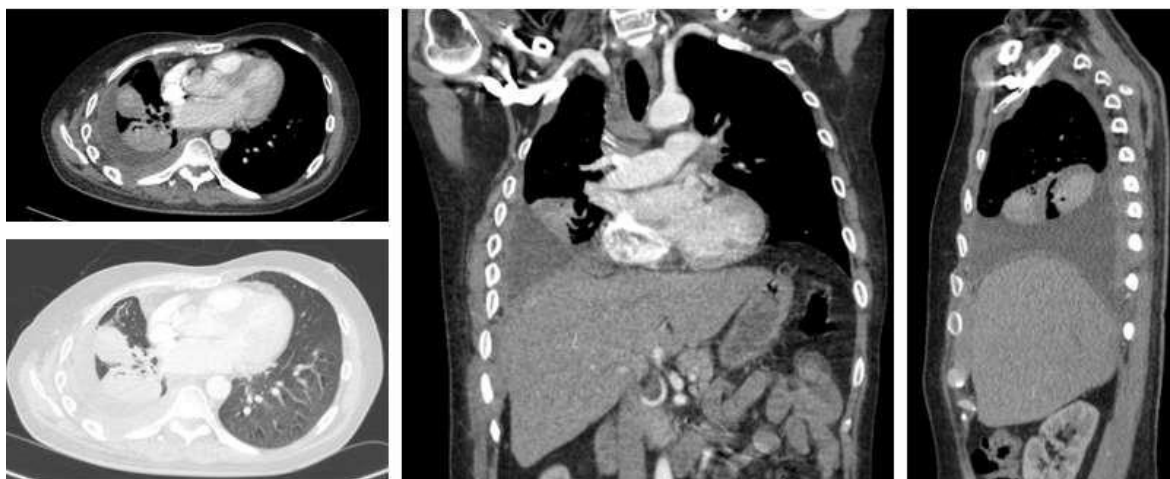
High-resolution computed tomography of the thorax shows lobulated soft-tissue lesions in the right lower lobe (largest 4.4 × 3.7 cm) with intralesional calcification, adjacent atelectasis, and anterior chest-wall infiltration, consistent with metastatic pulmonary involvement
